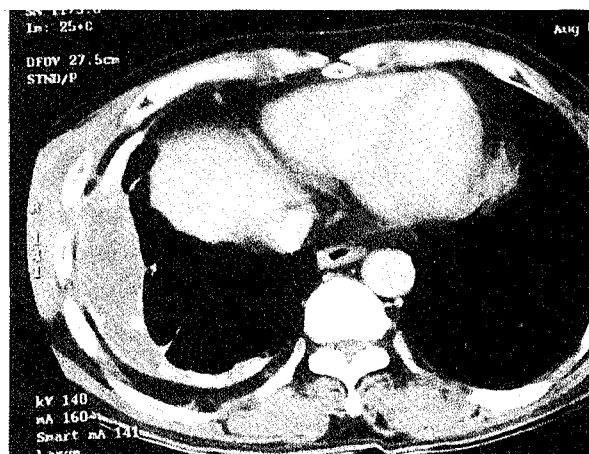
A hypodense mass lesion with marginal calcification in the lower right lung on chest CT.
